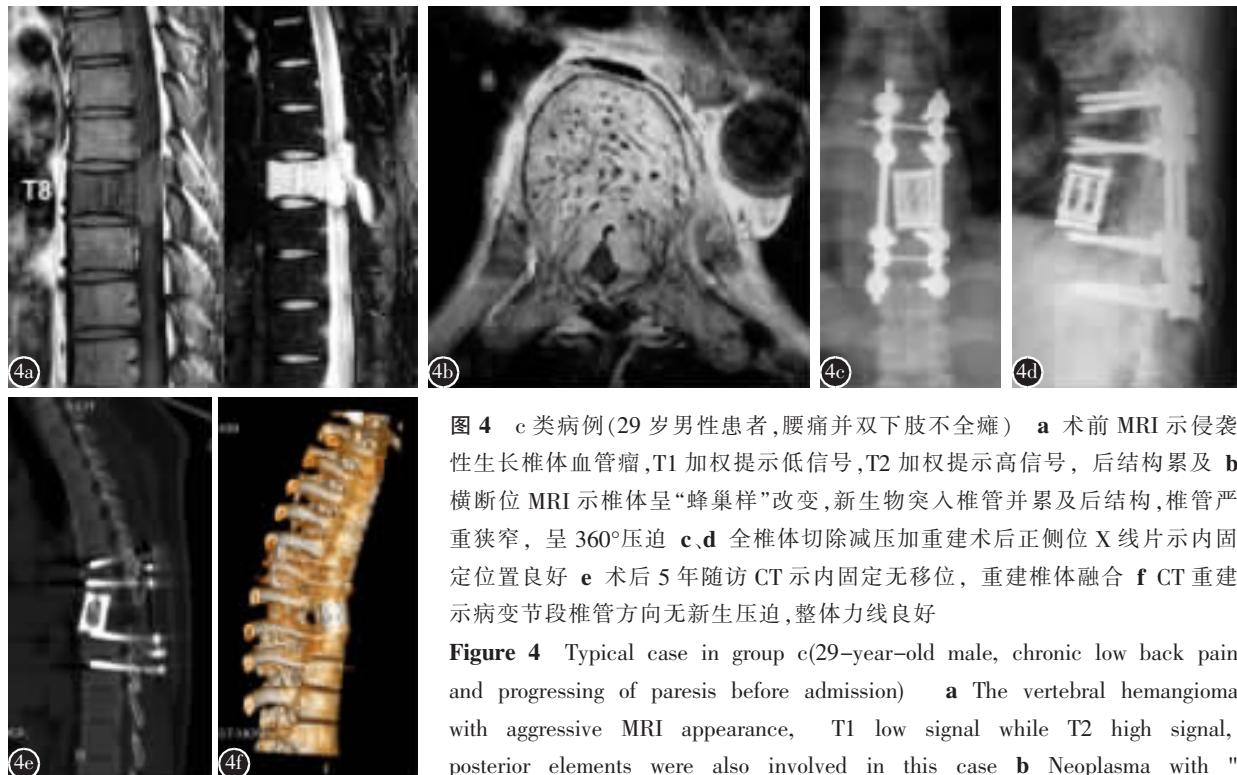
c 类病例(29岁男性患者,腰痛并双下肢不全瘫) a 术前 MRI 示侵袭性生长椎体血管瘤,T1 加权提示低信号,T2 加权提示高信号,后结构累及 b 横断位 MRI 示椎体呈“蜂巢样”改变,新生物突入椎管并累及后结构,椎管严重狭窄,呈 360°压迫 c、d 全椎体切除减压加重建术后正侧位 X 线片示内固定位置良好 e 术后 5 年随访 CT 示内固定无移位,重建椎体融合 f CT 重建示病变节段椎管方向无新生压迫,整体力线良好
